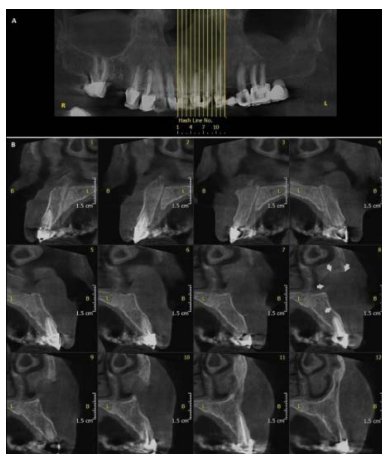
(A) Reformatted panoramic view and (B) Cross sectional cone beam computed tomography images show erosion in the buccal plate of anterior maxilla. Periapical alveolar bone is normal except for some PDL widening on the apex of central incisors (sections No. 1 and 5). The detectable periphery of the lesion is marked by arrows
